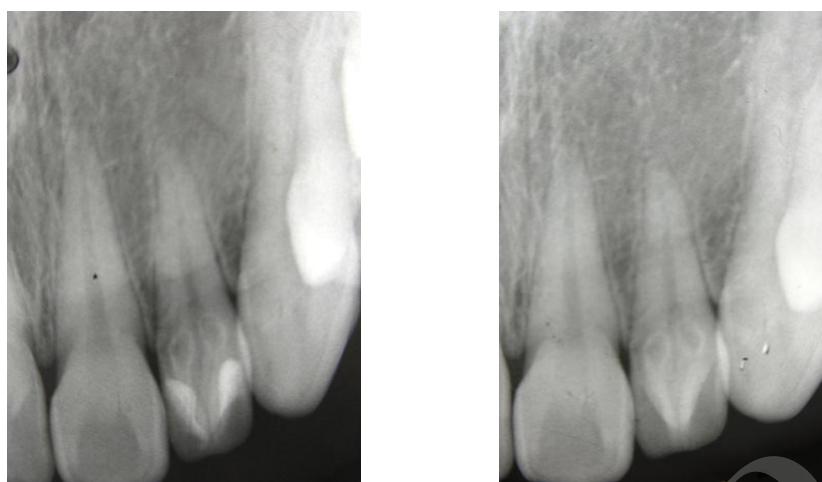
Periapical radiograph of the maxillary right lateral incisor. The white arrow indicates the DE and the black arrows point to the DIs. Note that the two DIs are distinct from the pulp chamber.
